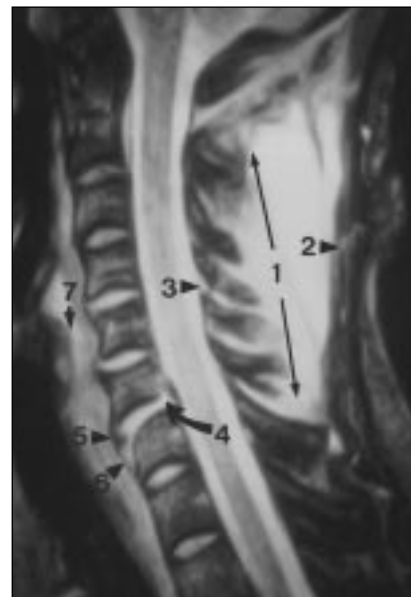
Teardrop fracture of C7 in 27-year-old man involved in motor vehicle crash. Sagittal gradient-echo MR image (TR/TE, 510/35; flip angle, 20°) obtained on 0.3-T MR scanner shows extensive tearing of interspinous ligaments (1), partial tear of nuchal ligament (2), flaval ligament tear (3), partial tear of posterior longitudinal ligament (4), anterior superior corner fracture of C7 vertebral body (5), stripping of anterior longitudinal ligament from anterior surface of C7 vertebral body (6), and prevertebral edema or hemorrhage (7).
